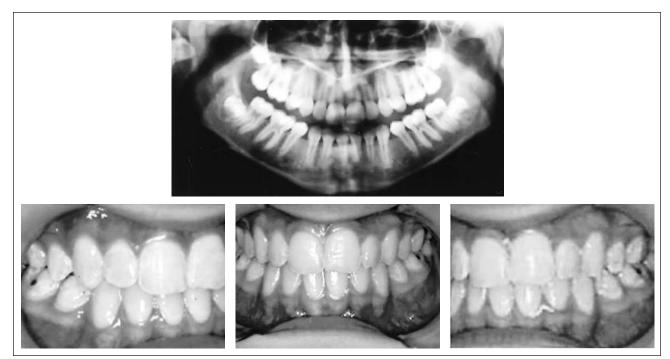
Panoramic radiography : no altered bony anatomy is present. The intraoral view puts in evidence a first molar class bilaterally.
